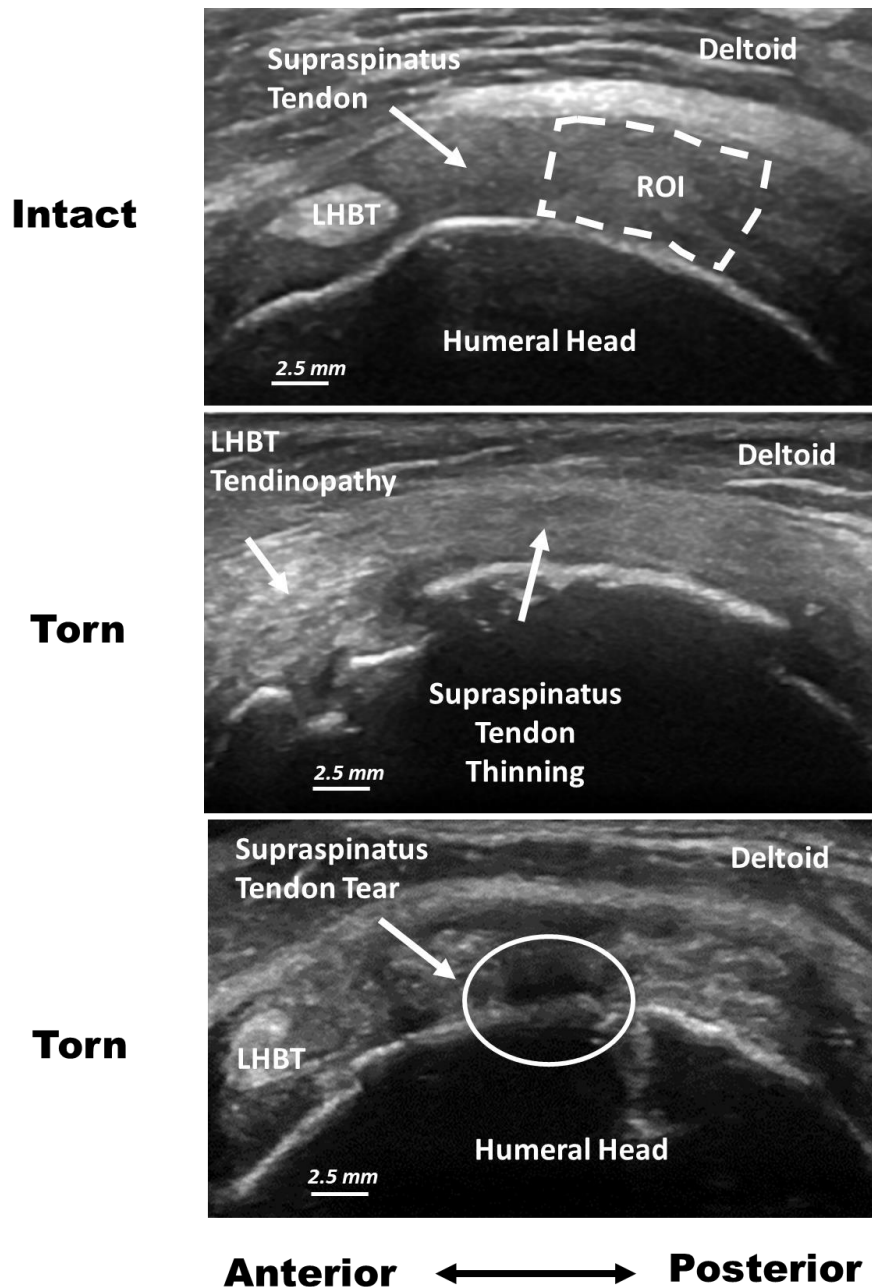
Transverse view of an intact and two torn supraspinatus tendons. A 1 cm wide region of interest (ROI) was measured 1 cm away from the posterior margin of the long head of the biceps tendon (LHBT). Quantitative ultrasound measures were made based on the grayscale distribution within the ROI. The middle image demonstrates signs of LHBT tendinopathy and supraspinatus tendon thinning, suggestive of a tear. For the far right image, the dark area within the circle indicates the location of the tear. Damage to the surface of the humeral head can be observed for both the middle and far right image.
